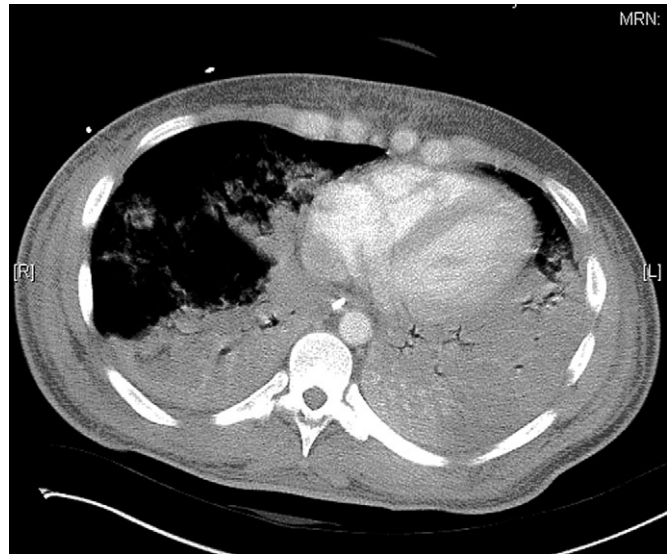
Computed tomography scan of patient with ARDS due to pulmonary disease (i.e., aspiration pneumonia) demonstrating extensive consolidation with normal lung and ground-glass opacification. (Courtesy of M. Cereda, M.D.)
